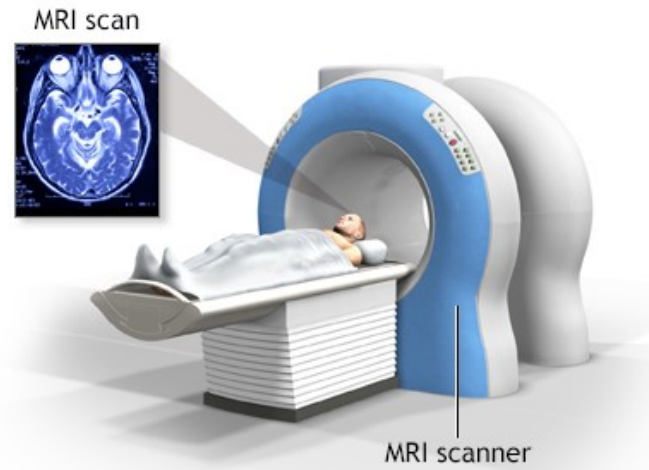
The magnetic resonance imaging (MRI) scanner
